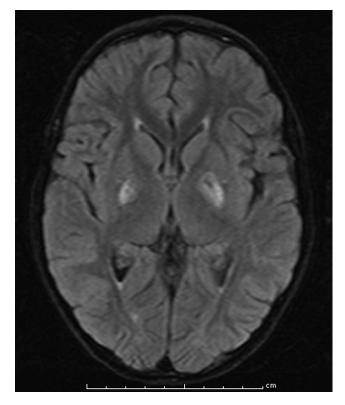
After 1 month, follow-up magnetic resonance imaging indicates a regression of the lesions.
